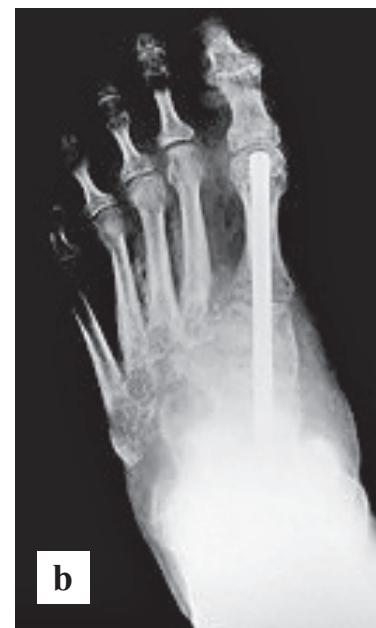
Postoperative plain radiographs, a) axial intramedullary fixation of the medial column extending beyond the zone of fusion from talus to first metatarsal, b) healing of the talonavicular, navicular-cuneiform and 1st metatarsal-cuneiform joint fusions on dorsoplantar view
